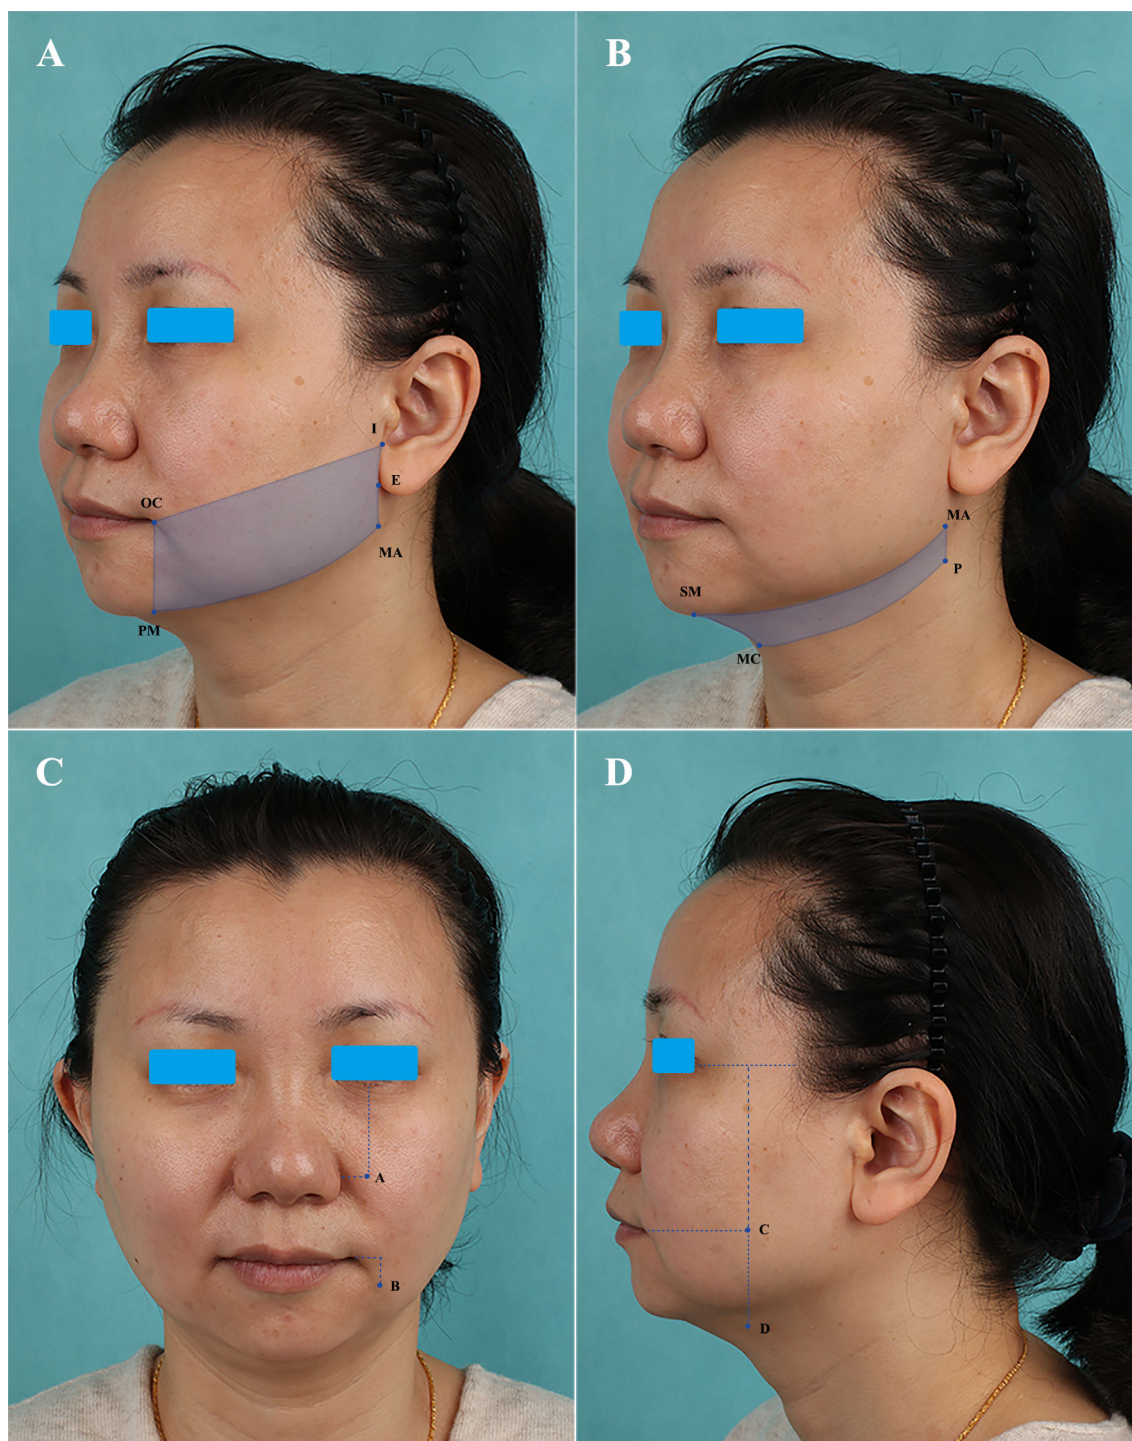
A and B Lower face and submental tightening were evaluated using volumetric changes in the preestablished area of interest. C and D On ultrasound images, the depth
